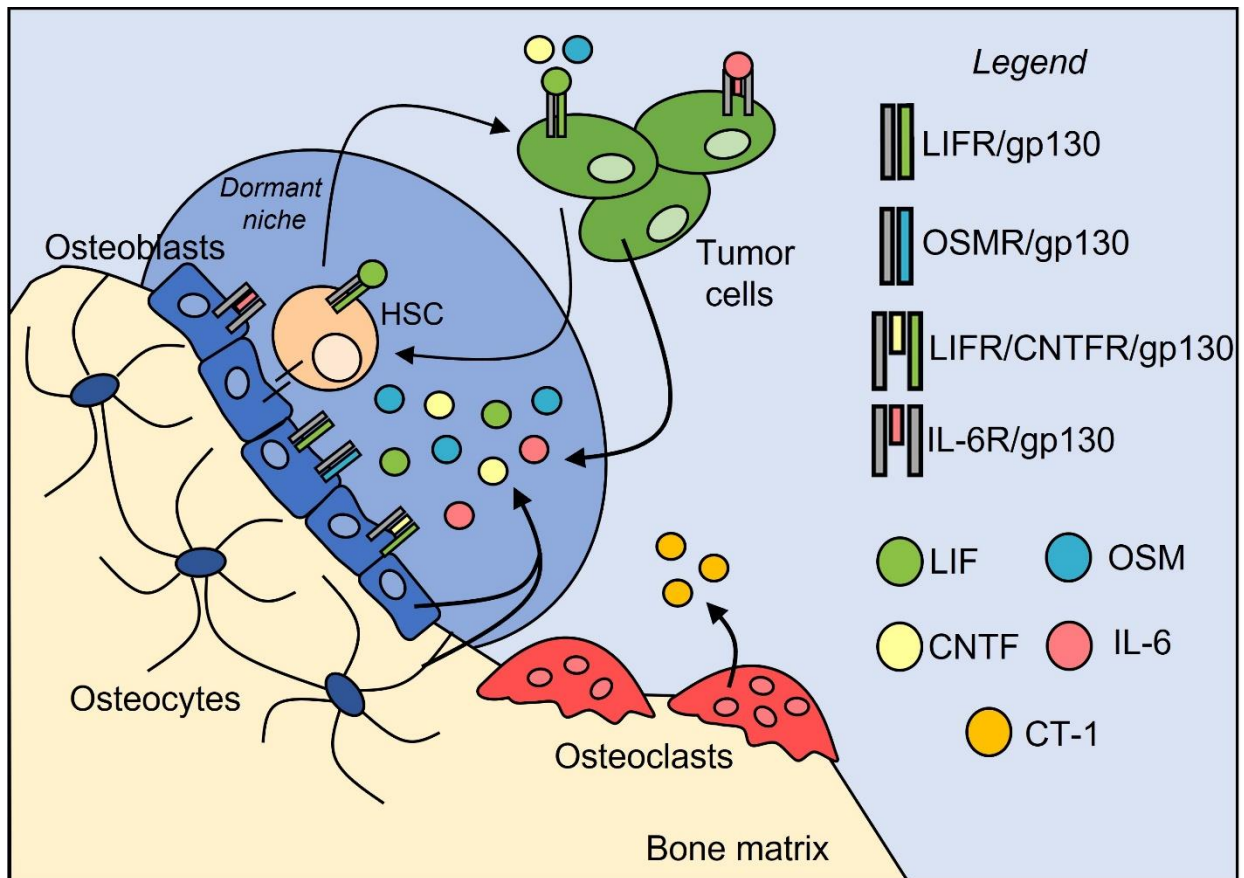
Bone disseminated tumor cells compete with hematopoietic stem cells (HSCs) in the endosteal niche, where they encounter pro-dormancy cytokines in the microenvironment. Tumor cells that disseminate into the bone marrow are proposed to compete with HSCs for the endosteal niche, which maintains dormancy through cell-cell interactions and secreted factors, including the gp130 cytokines. These cytokines normally send pro-dormancy signals to the HSCs to maintain their quiescence, and when tumor cells compete for this niche are likely to encounter the same cytokine milieu. Both HSCs and breast cancer cells express LIFR, although LIFR is markedly down-regulated in more aggressive breast cancer cells [69]. This suggests that both HSCs and breast cancer cells are capable of responding to LIF, OSM, and CNTF secreted within the bone marrow microenvironment. The source of these cytokines in the pro-dormancy niche are bone-lining osteoblasts and osteocytes embedded within the bone matrix. Osteoclasts do not express most of the gp130 cytokines, but do express CT-1, which can also bind to LIFR. It is unclear how this might contribute to the pro-dormancy niche along the quiescent osteoblast-lined surface.
